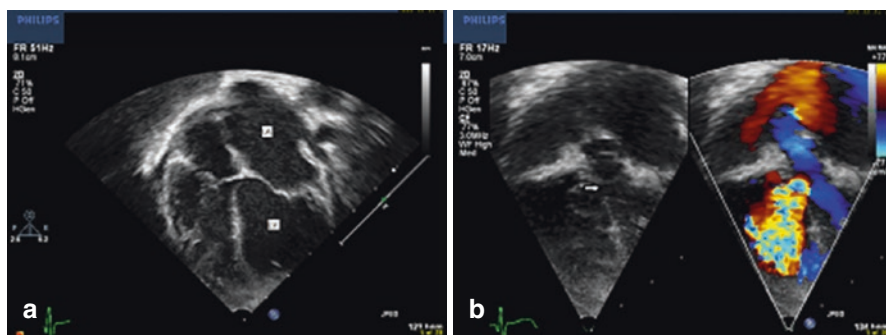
(a) Apical four chamber view showing the dilated left atrium (LA) and left ventricle (LV). (b) Color comparison of apical five-chamber view showing a large ventricular septal defect (arrow) and the color flow from the LV to the right ventricle
